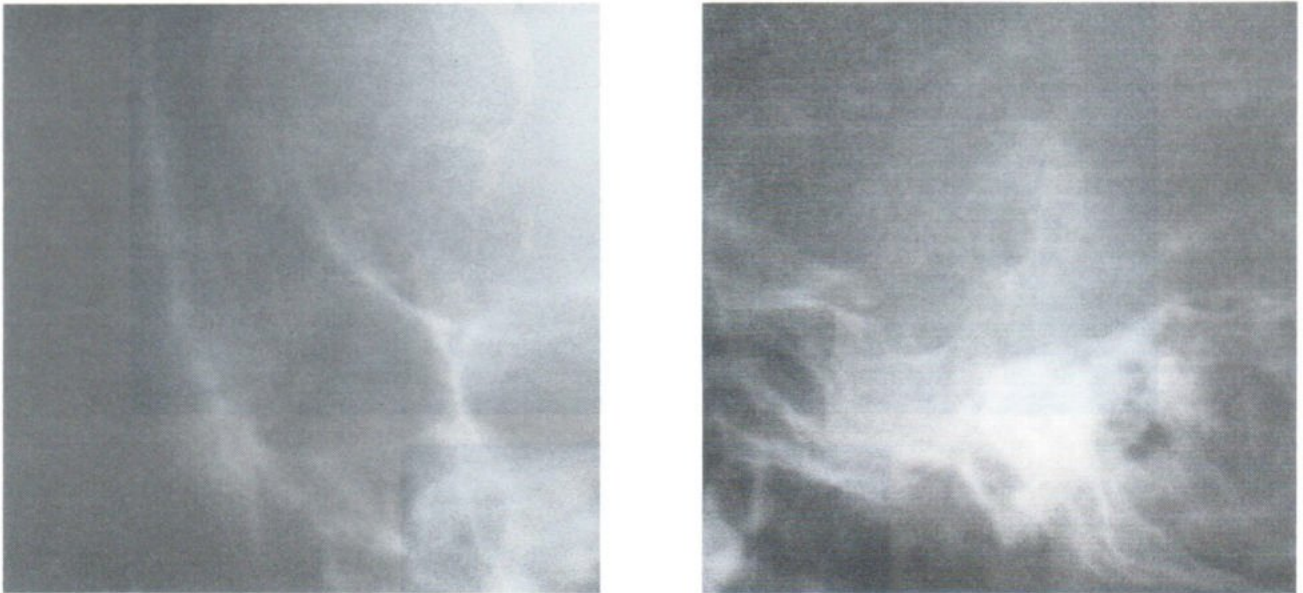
Case 2. PA and lateral plain films of the skull revealed an ill defined border dense area in the right temporal bone with irregular outline of the tables.
